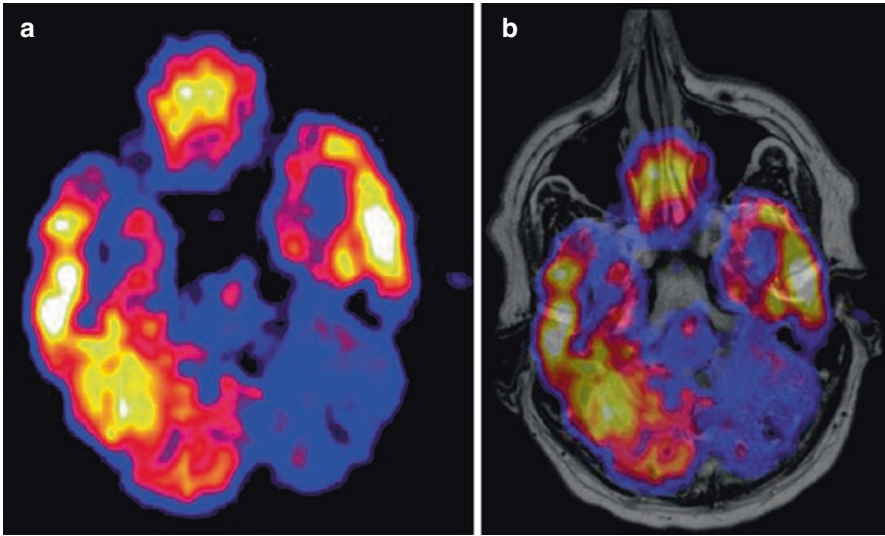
Same case as in Fig. 22.5 showing hypometabolism in the left cerebellar hemisphere and supratentorial hypometabolism in the right (temporal) hemisphere on [^{18}F]FDG PET (a). Fusion of [^{18}F]FDG PET-MRI (b)
